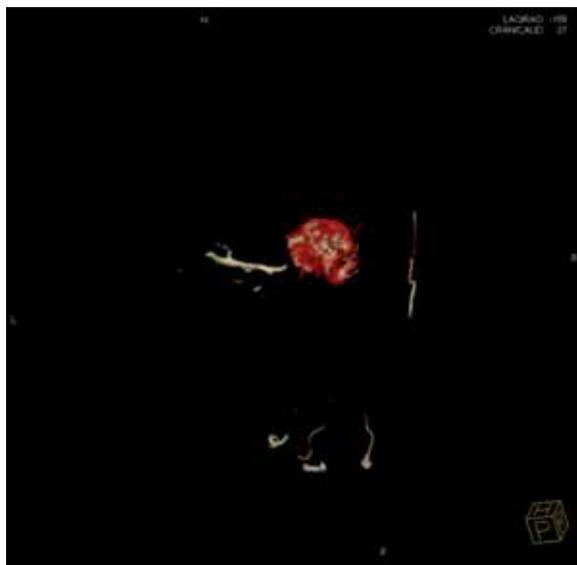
CT angiography revealed weak opacification of the left middle cerebral artery (M1 segment) in early and late phase. External carotid arteries were opacified, indicating that contrast medium had been injected correctly.
